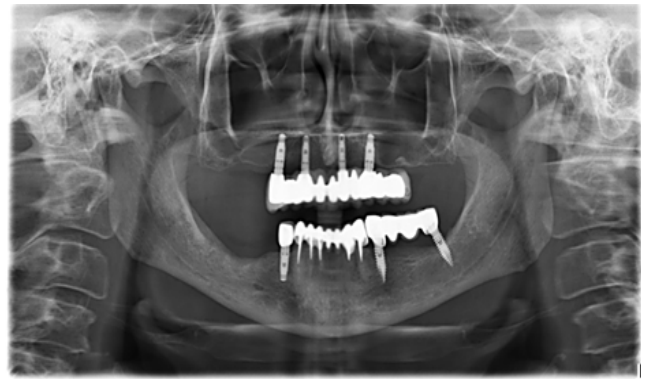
Postoperative OPG radiograph
